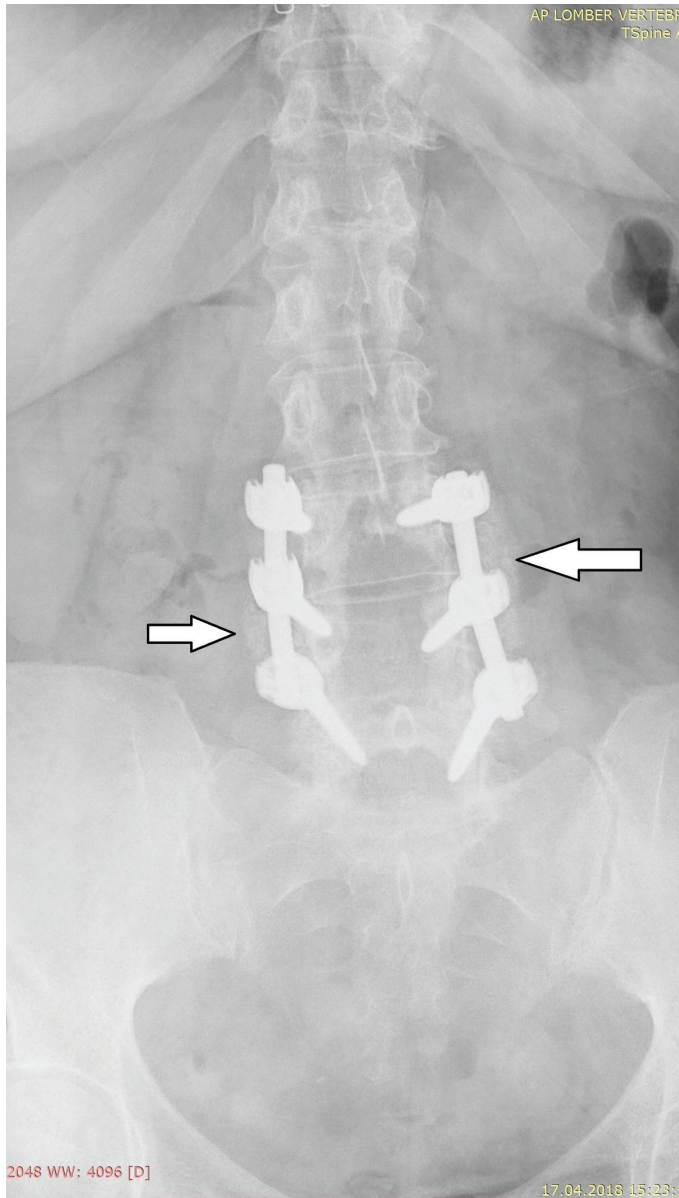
Stage 2 fusion. Solid fusion is noted between transverse processes (white arrows) on the posteroanterior lumbar roentgenography
